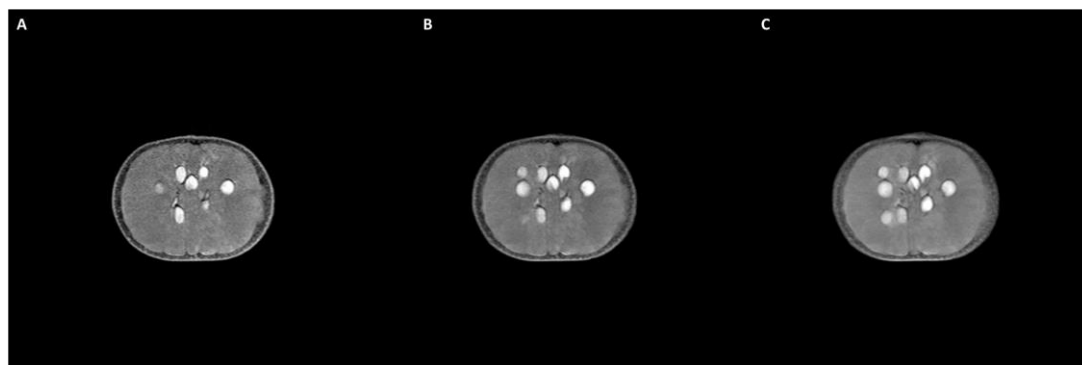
MRI Image of Tangerine fruit acquired under slice thickness of 1.5 (A), 3.0 (B) and 5.0 (C) millimeters, respectively.
